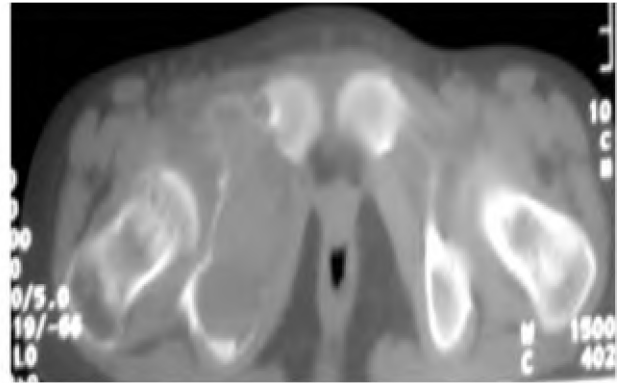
Axial CT bone window showing the involvement of the quadrilateral plate, anterior and posterior columns of the acetabulum.
